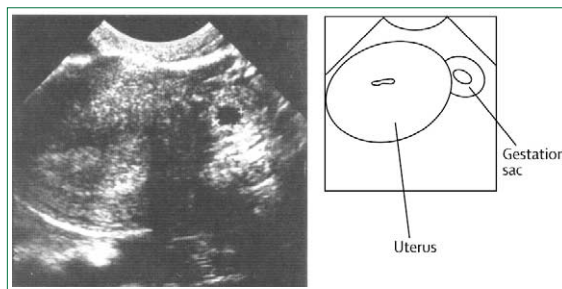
Transvaginal ultrasound view of ectopic pregnancy at 6 weeks' gestation
